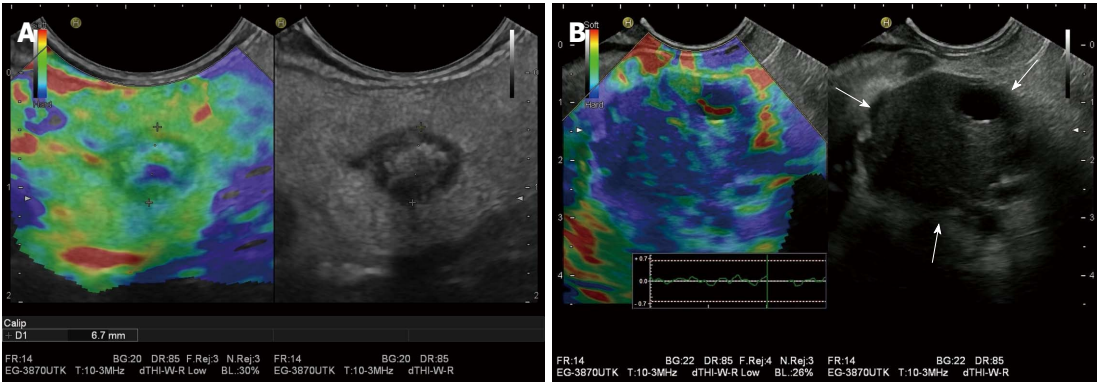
Benign and malignant pancreatic masses on endoscopic ultrasound elastography. A: A pancreatic teratoma is shown as heterogeneous soft (green) pattern (left: EUS elastography image; right: B-mode image); B: A pancreatic ductal adenocarcinoma appears stiffer (blue) than the adjacent normal pancreatic parenchyma, probably due to the presence of fibrosis and marked desmoplasia.
